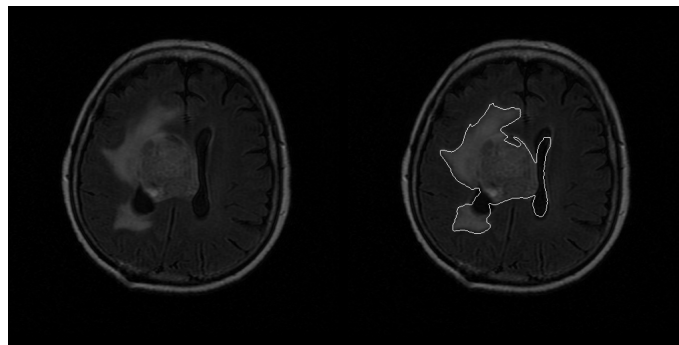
Examples of classification results on Patient 2 by level set method (FLAIR images)
